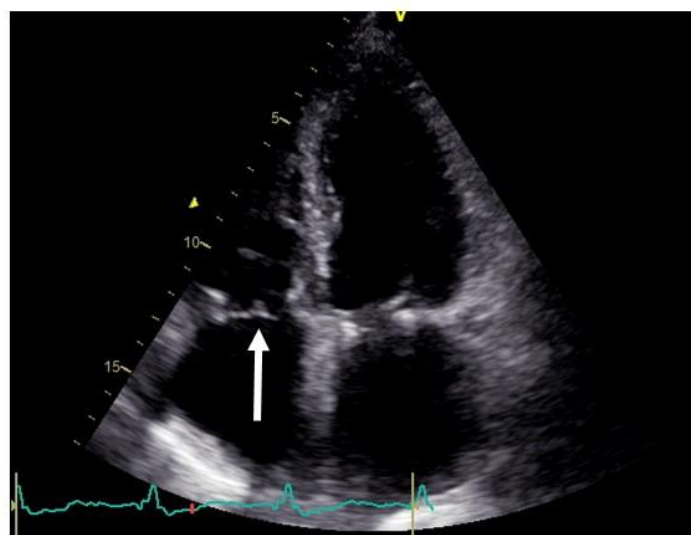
Transthoracic echocardiography (Apical 4-chamber view) showing postoperative status with tricuspid bioprosthesis (white arrow) properly closing during systole.
